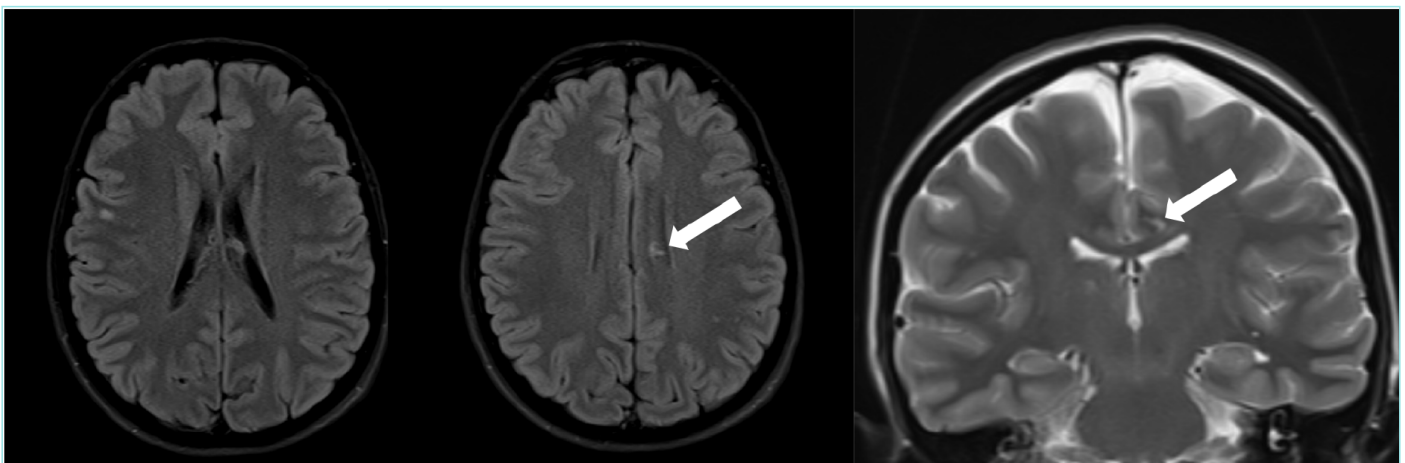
FLAIR images of a patient, right frontoparietal and left callososeptal (white arrows) hyper-intense lesions. The complaints of this 35-year-old patient were the inability to remember things to do, forgetting topics discussed at work in a short time, headaches and feelings of instability.
